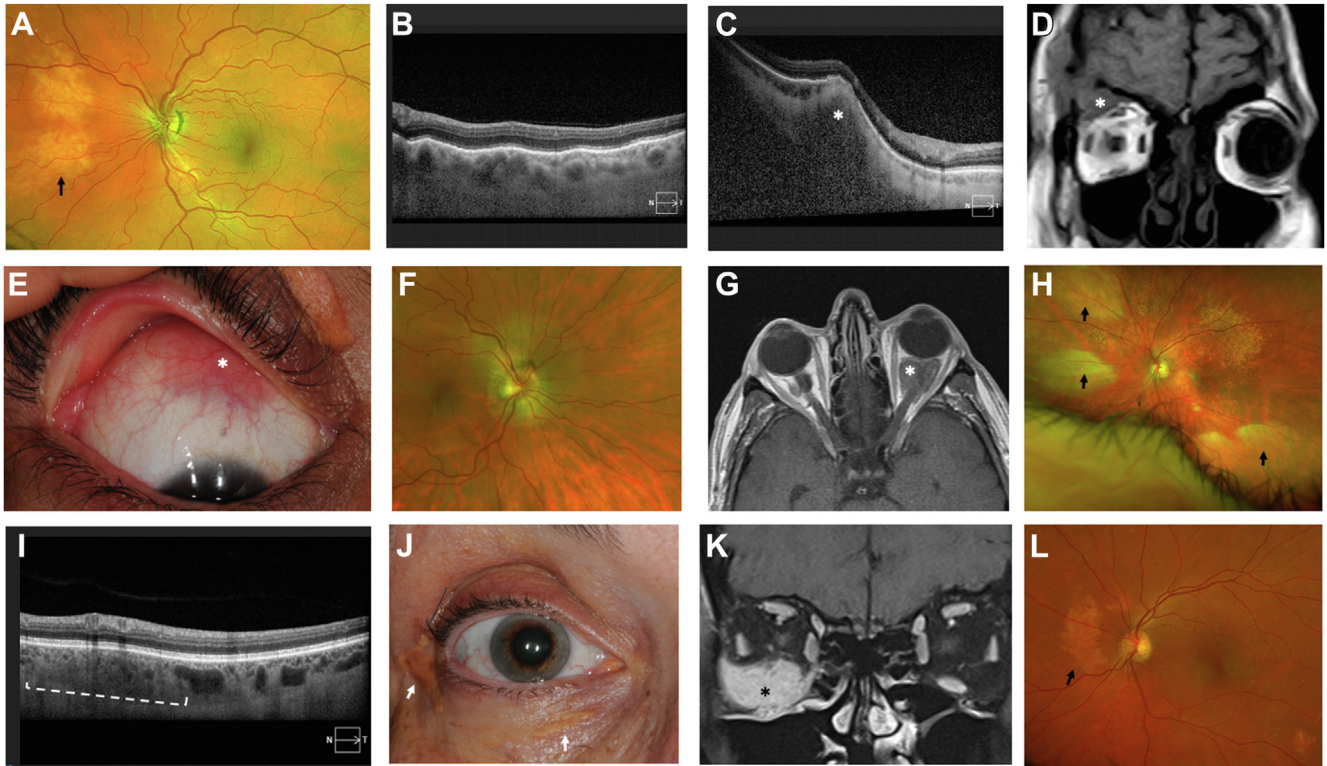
Representative patient images. A, Color fundus photo of choroidal disease in Erdheim-Chester Disease (ECD) patient 7 (arrow). B, OCT of choroidal disease in ECD patient 10 showing undulating choroid. C, OCT of sclerochoroidal disease in ECD patient 12 (asterisk). D, Magnetic resonance imaging (MRI) of orbital disease in ECD/Langerhans cell histiocytosis (LCH) patient 9 (asterisk). E, External photo of episcleral disease in ECD/LCH patient 4 (asterisk). F, Color fundus photo of optic nerve infiltration in ECD patient 11 (arrows). G, MRI of orbital disease in ECD patient 1 (asterisk). H, Color fundus photo of choroidal disease in RDD patient 5 (arrows). I, OCT of choroidal disease in RDD patient 8 (white dashed line). J, External photo of eyelid disease infiltrating disease mimicking xanthelasma in ECD patient 6 (arrows). K, MRI of orbital disease in Xanthogranuloma patient 3 (asterisk). L, Color fundus photo of choroidal disease in ECD patient 2 (arrow).
